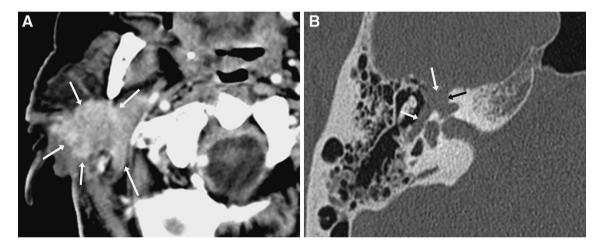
Perineural spread of tumor. a Axial CT image in soft tissue algorithm shows an irregularly marginated enhancing mass in the right parotid gland infiltrating toward the skull base toward the stylomastoid foramen (arrows), extending along the facial nerve. b Axial
